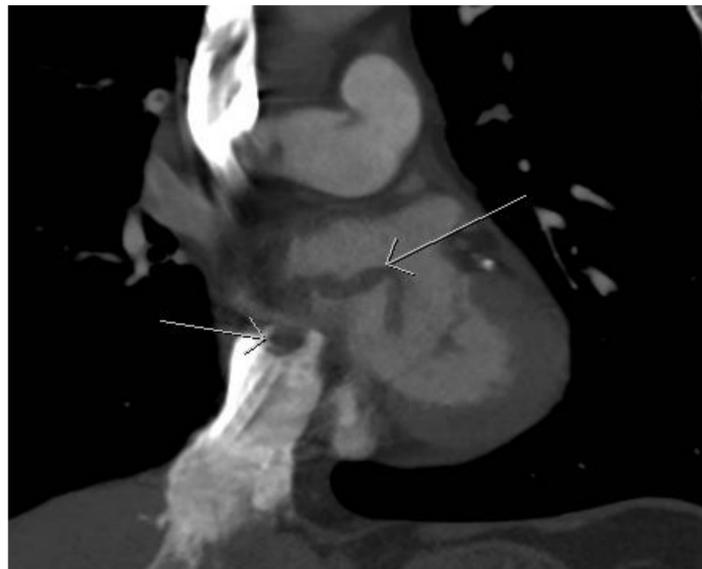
CTA chest with linear thrombus extending from the right to left atria.
